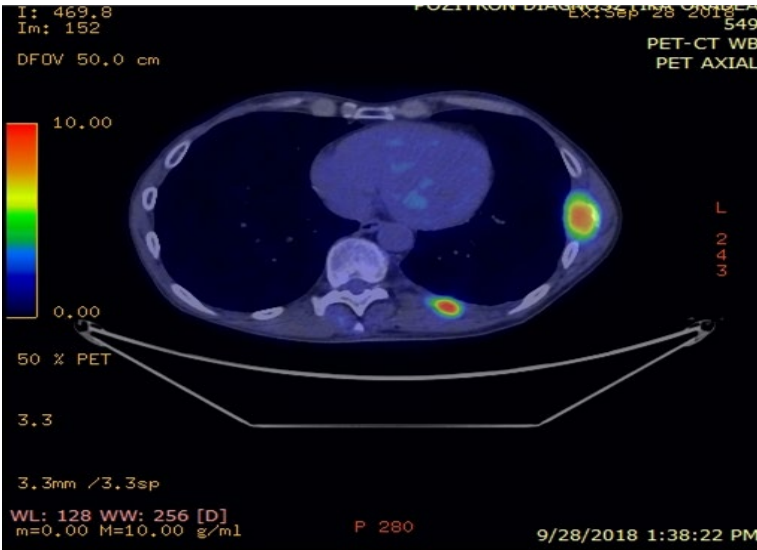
PET-CT: Metastases on the 7th and 10th ribs
